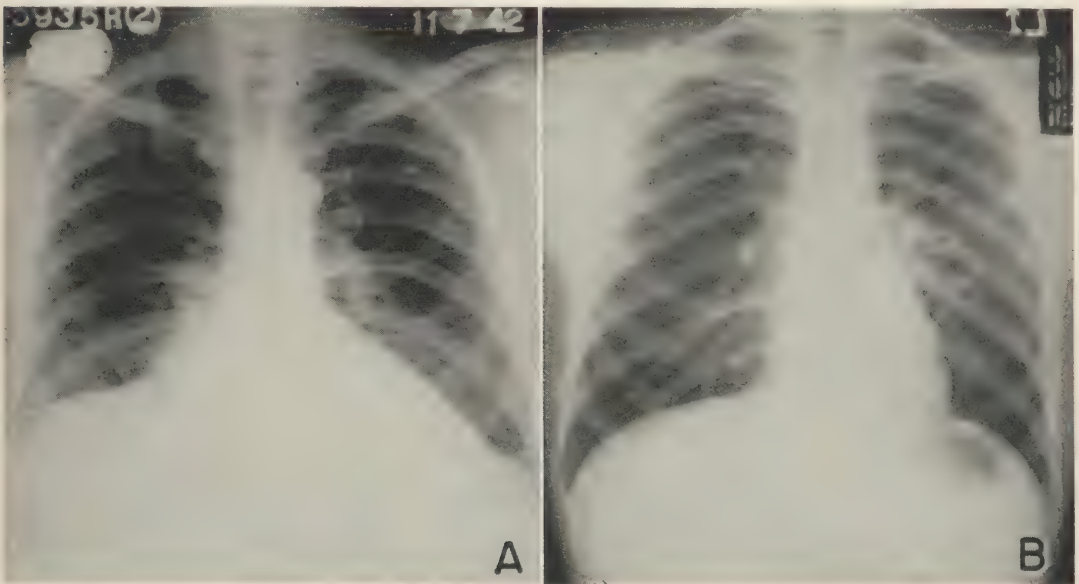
a.* Case 12. Slight medial atelectasis and inflammatory infiltrate in the right lower lobe. The adenoma was 3 cm. in diameter, of carcinoid type, and was located in the lower lobe (Fig. 5b) although that is not evident in the roentgenogram. Neg. 84775. *b.* Case 23. Inflammatory infiltrate and abscess in the left lower lobe secondary to carcinoid type of adenoma situated in the lower lobe bronchus. Neg. 83464.
